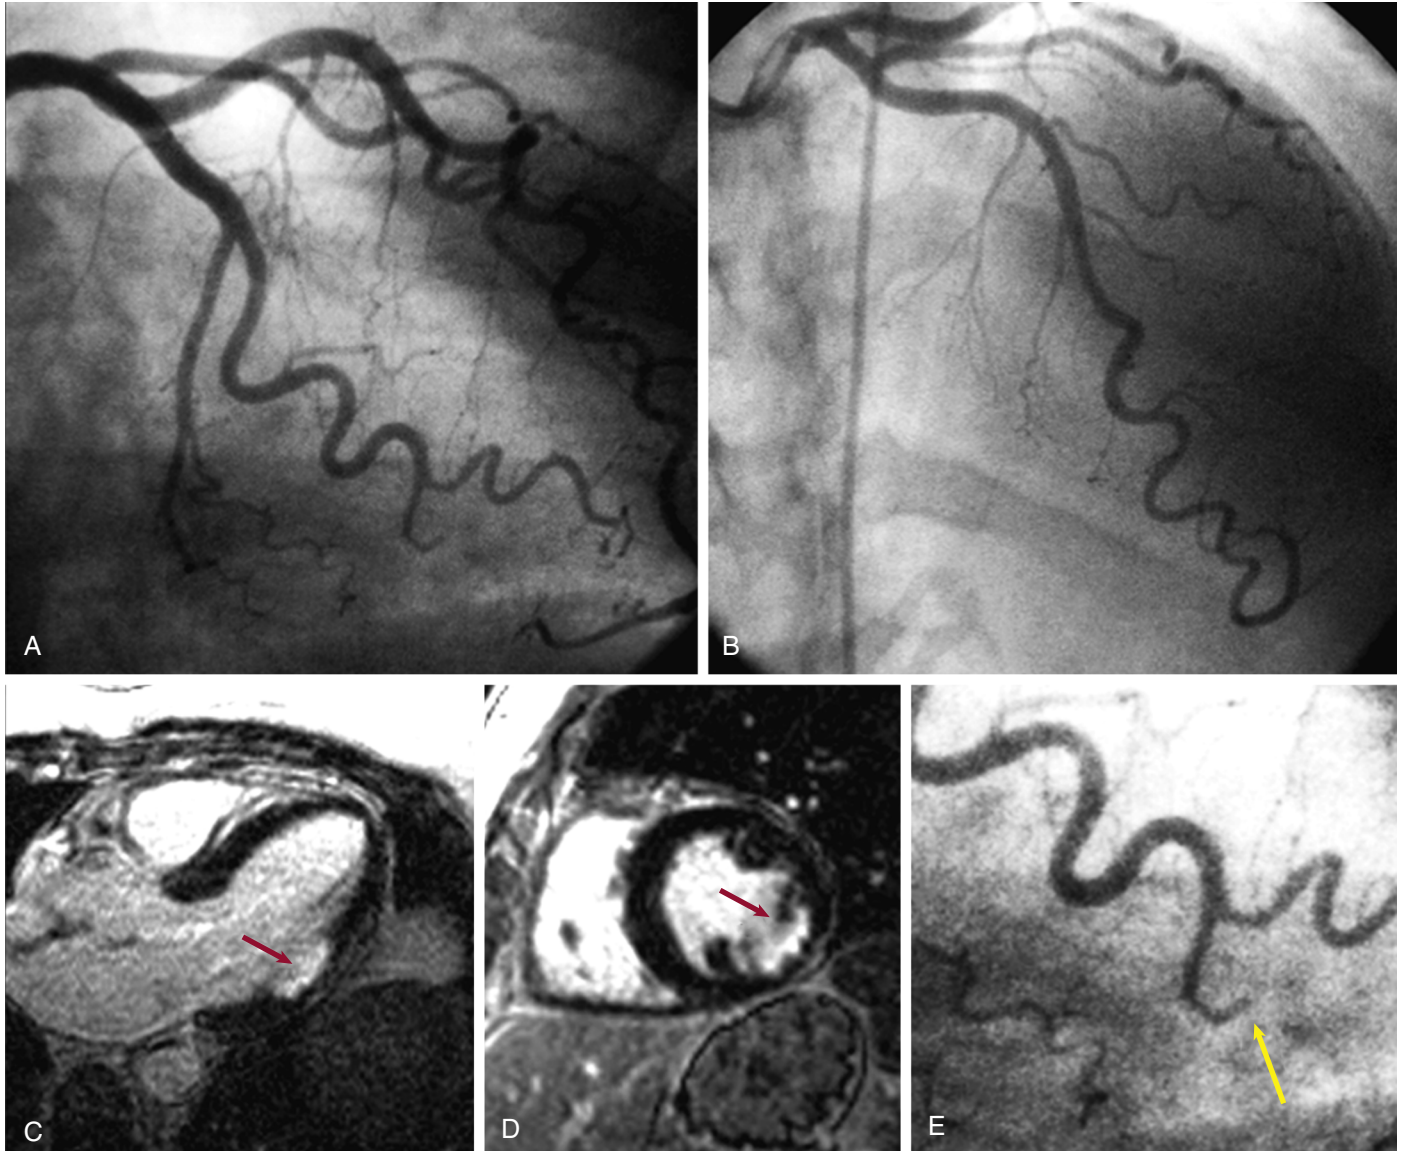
Images from a patient with a non-ST-elevation myocardial infarction. The initial diagnostic coronary angiogram was interpreted as negative (images A and B are selected still frames), and the patient was referred for cardiac resonance imaging. (C and D) Delayed-enhancement cardiac magnetic resonance images show a focus of hyperenhancement in the inferolateral wall (red arrows), consistent with a circumflex territory myocardial infarction. Upon review of the angiogram (E, which is a magnified image from the series shown in A), a subtle occlusion of a small obtuse marginal branch is noted (yellow arrow in E). For an additional presentation of this image, click here.
